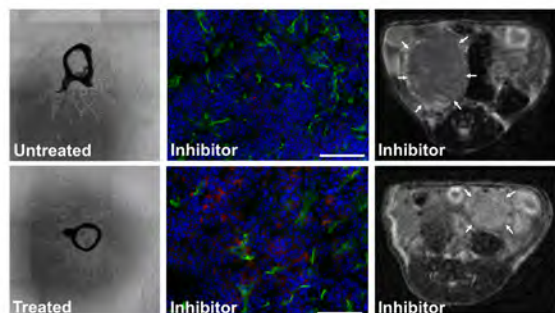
Enhanced vascular sprouting is observed in response to a priming agent (treated) in the aortic ring assay (left). The amount of FAP-positive fibroblasts (middle panels, red: FAP, green: blood vessels) and tumor sizes (right, tumors marked by arrows on the MR images) differ between individual tumors upon treatment with immune checkpoint inhibitors.
